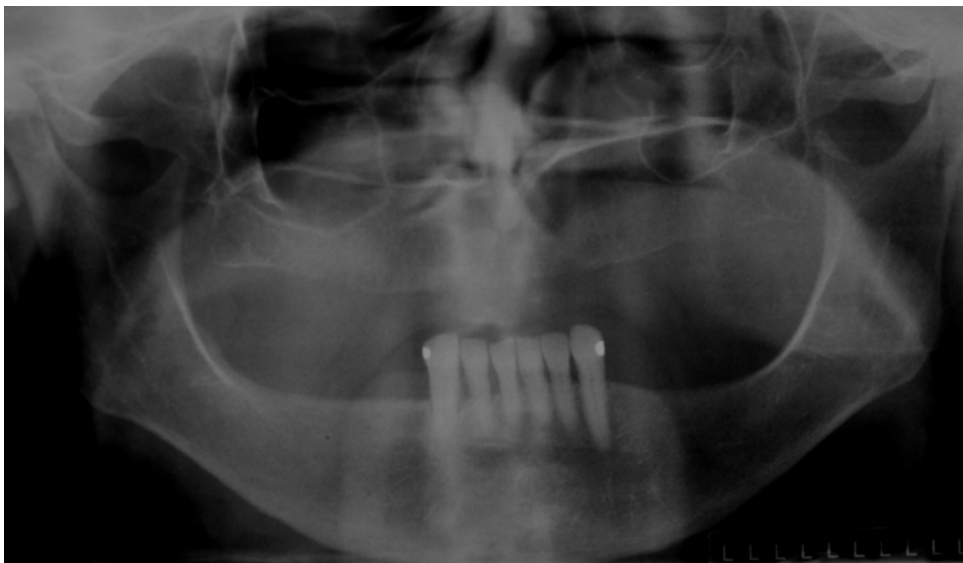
Diagnostic panoramic radiograph.
